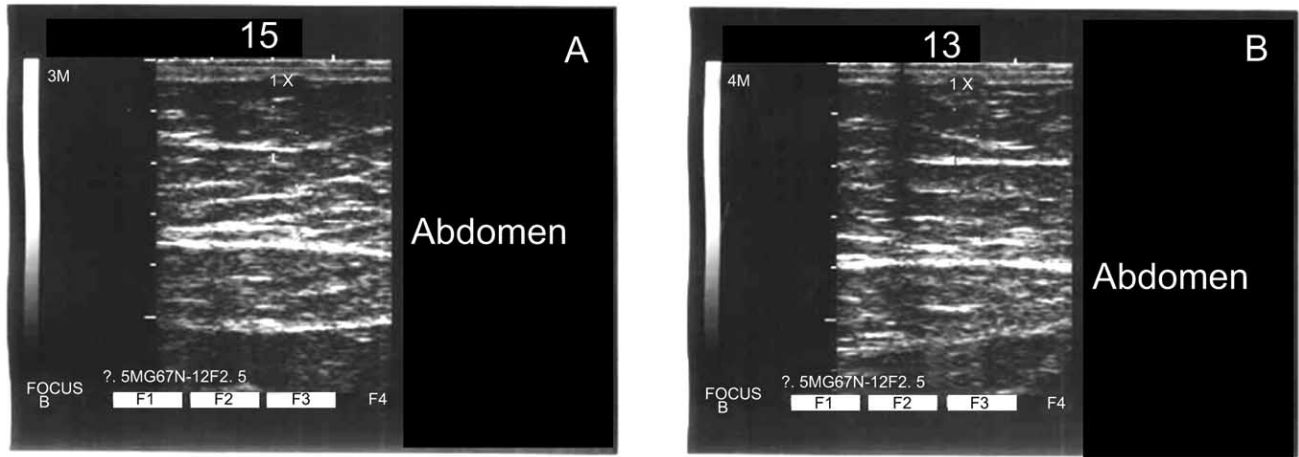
Fat thickness assessment by ultrasound before (A) treatment and after (B) treatment, shows thinning of the subcutaneous fat layer from 15 mm to 13 mm (reduction of 2 mm). This patient was treated on the abdomen.
